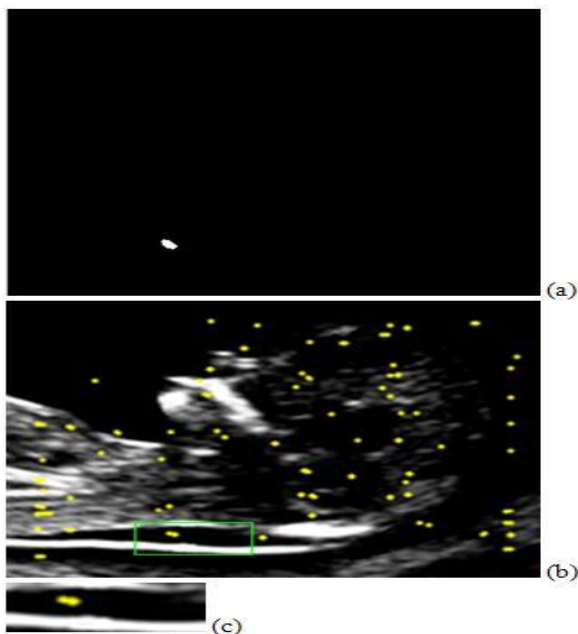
Experimental result of ROI extraction. (a) The window with highest probability. (b) ROI on sample ultrasound image. (c) Resultant windowed NT region
